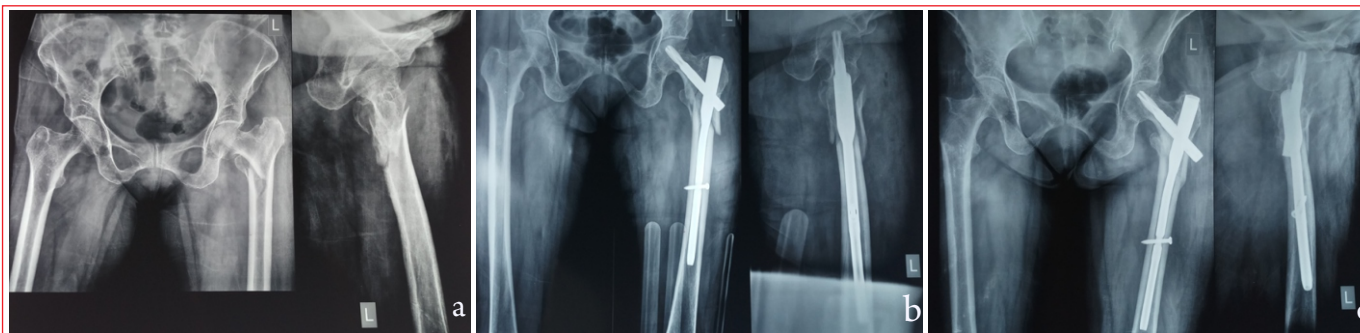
2a: 75-years female with AO 31A3 fracture of left hip, 2b: She was treated with CRIF with Long CMN, 2c: Follow-up radiograph at 1 year showing complete union
